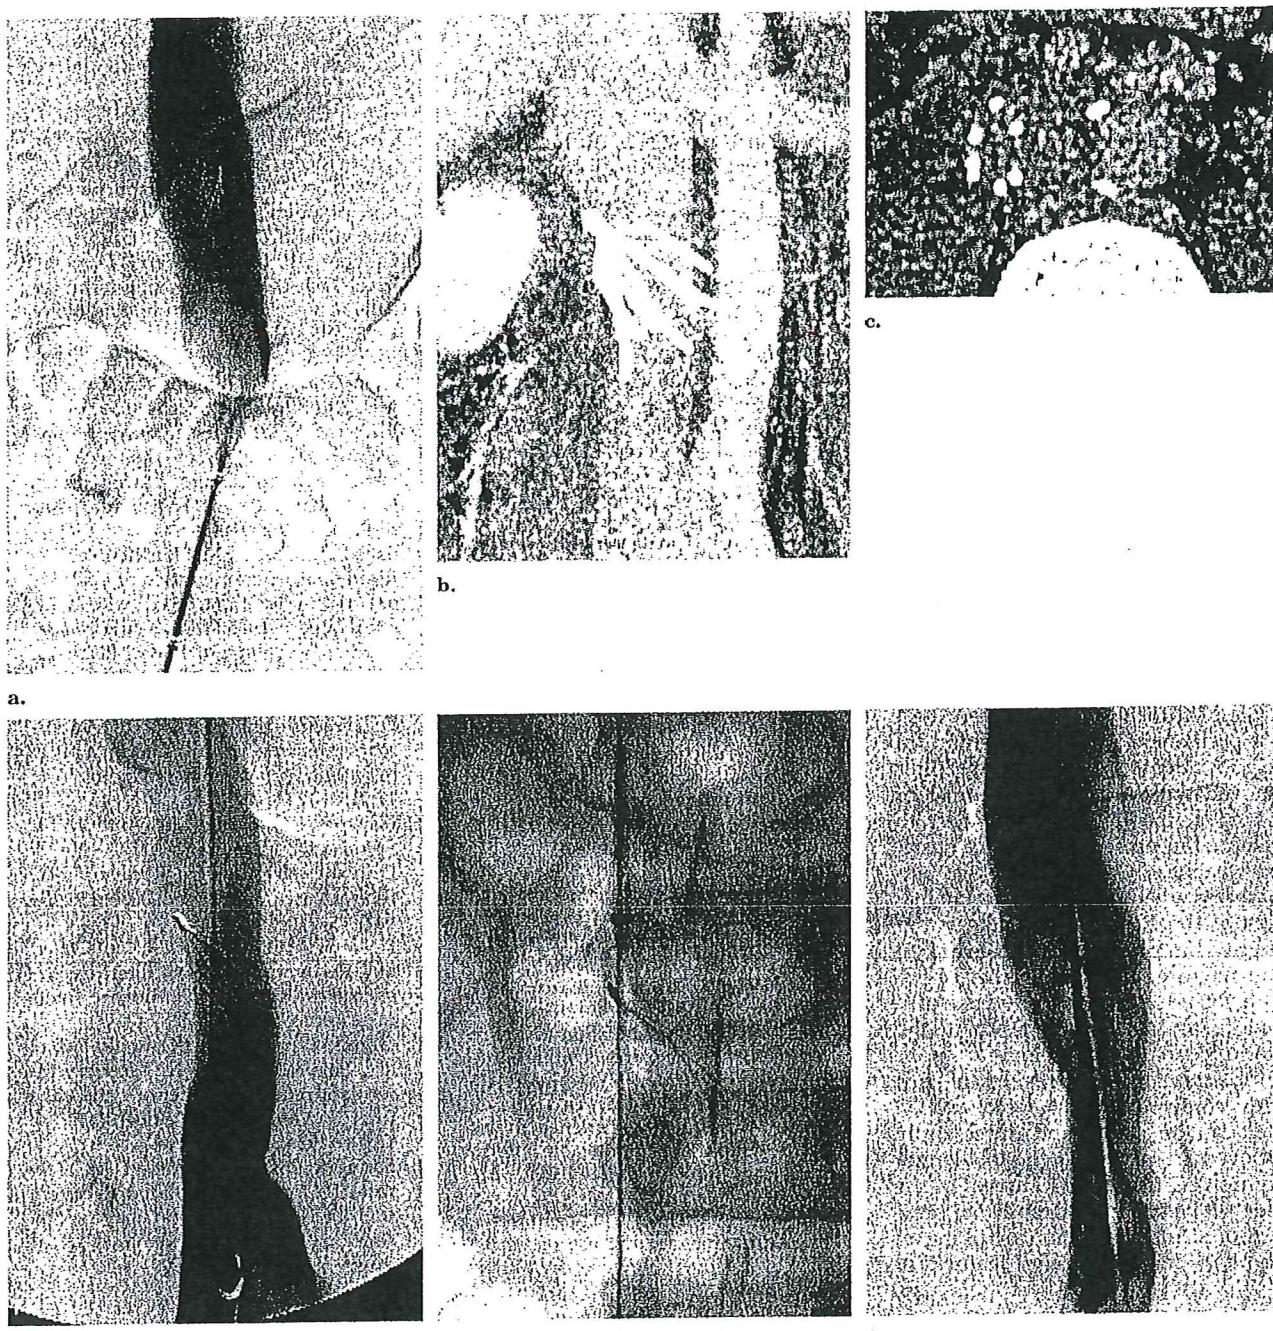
(a) Inferior vena cavogram obtained after placement of the Recovery G2 filter in an adequate position in 25-year-old man with lower extremity DVT and temporary contraindication to anticoagulation. (b) Coronal reconstruction of a computed tomographic (CT) scan obtained 2 months after filter placement. There is absence of entrapped thrombus; however, severe tilting of the filter is observed and caval penetration of filter struts is suspected. (c) Axial CT scan helps confirm the penetration of two filter legs that lie in close contact with the abdominal aorta. (d) Angiogram of the IVC before filter removal helps confirm severe tilting of filter. (e) On digital radiograph, an Amplatz wire has been placed toward the side where the shortest distance is present between the filter apex and the caval wall to guide the retrieval cone to the filter apex. (f) Follow-up vena cavogram obtained after filter removal reveals the absence of caval injury.
